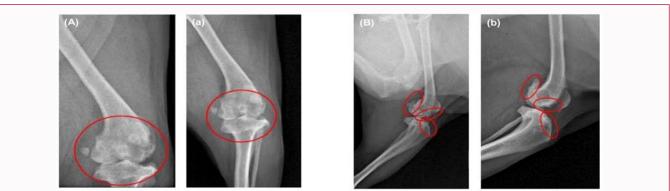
Representative results of changes of joint structure after Membrane-Free Stem Cell Extract (MFSCE) treatment. Radiography of OA at 0 day (A, B) was significantly improved 28 days after MFSCE treatment (a, b).
